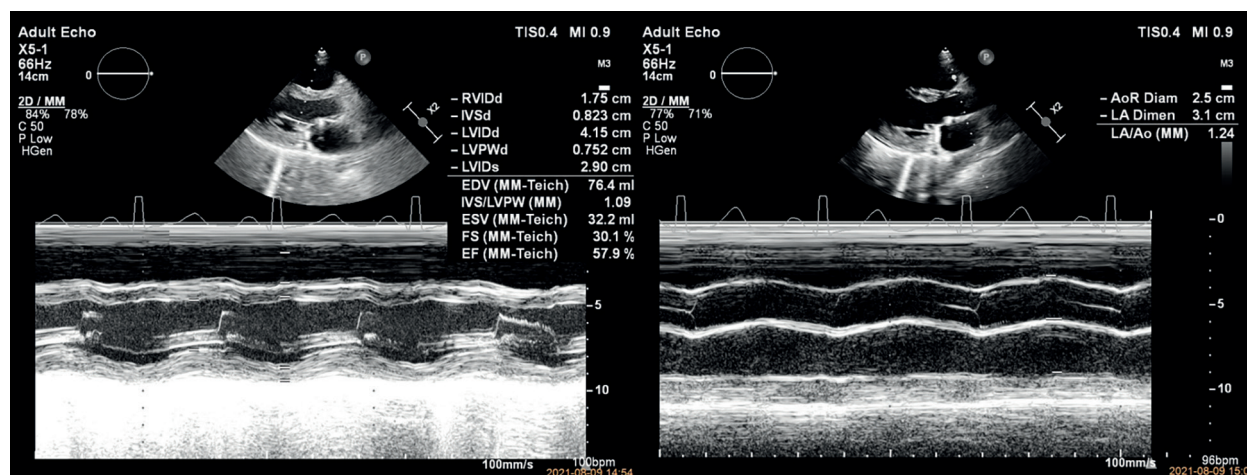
M-mode echocardiography. Impaired left ventricular function (ejection fraction = 57.9%) and enlarged left atrium/aorta = 1.24
